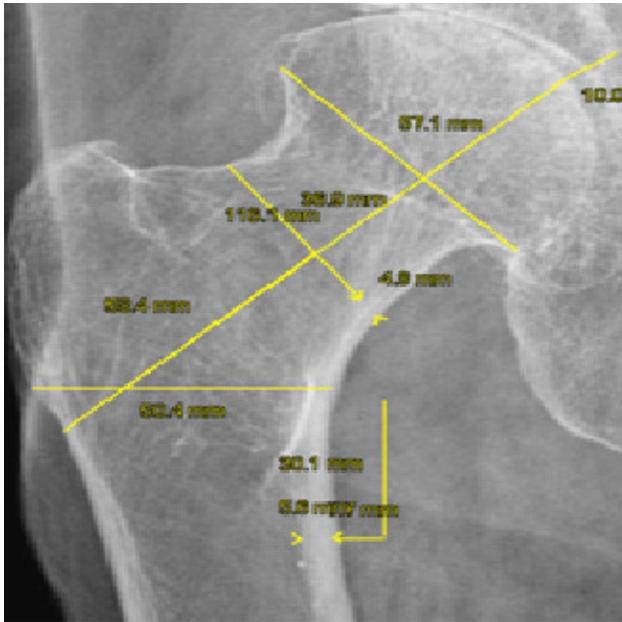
Hip geometrical measurements on a digital radiograph of osteoporotic Post Menopausal Indian woman aged: 80, the measured Total hip BMD by the DXA in the same individual was: 0.506 g/ Cm²
